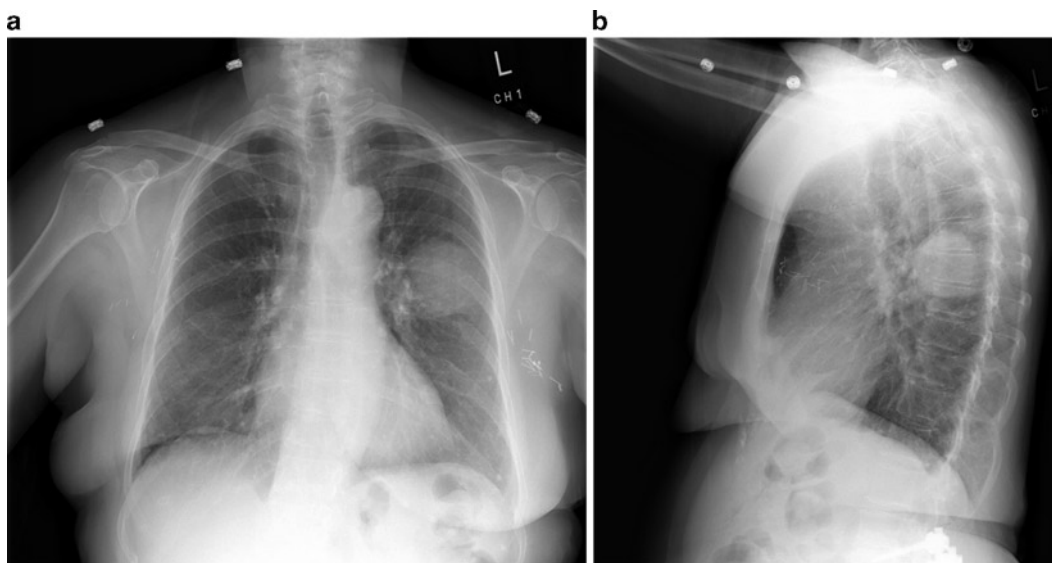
(a, b) Chest X-ray of a female patient with a carcinoma of the left lower lobe undergoing a lobectomy.
